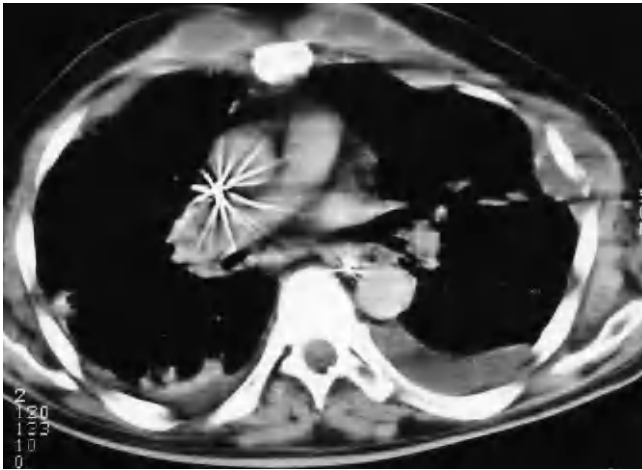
Computed tomography scan of the chest showing collections along the chest wall and in the left parasternal region.
